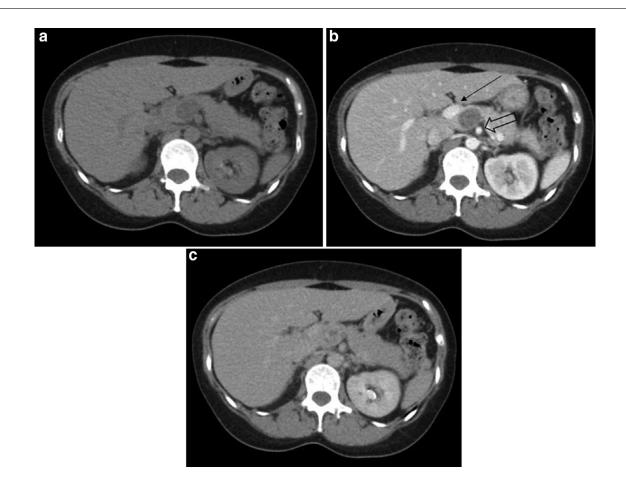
Axial noncontrast, portal venous, and excretory phase (left to right) CT images demonstrate a well-circumscribed, hypodense 2.5 x 2.0 cm mass in the neck of the pancreas which demonstrates progressive delayed enhancement. Note the proximity of the mass to the main portal vein (solid arrow) and superior mesenteric artery (unfilled arrow).
